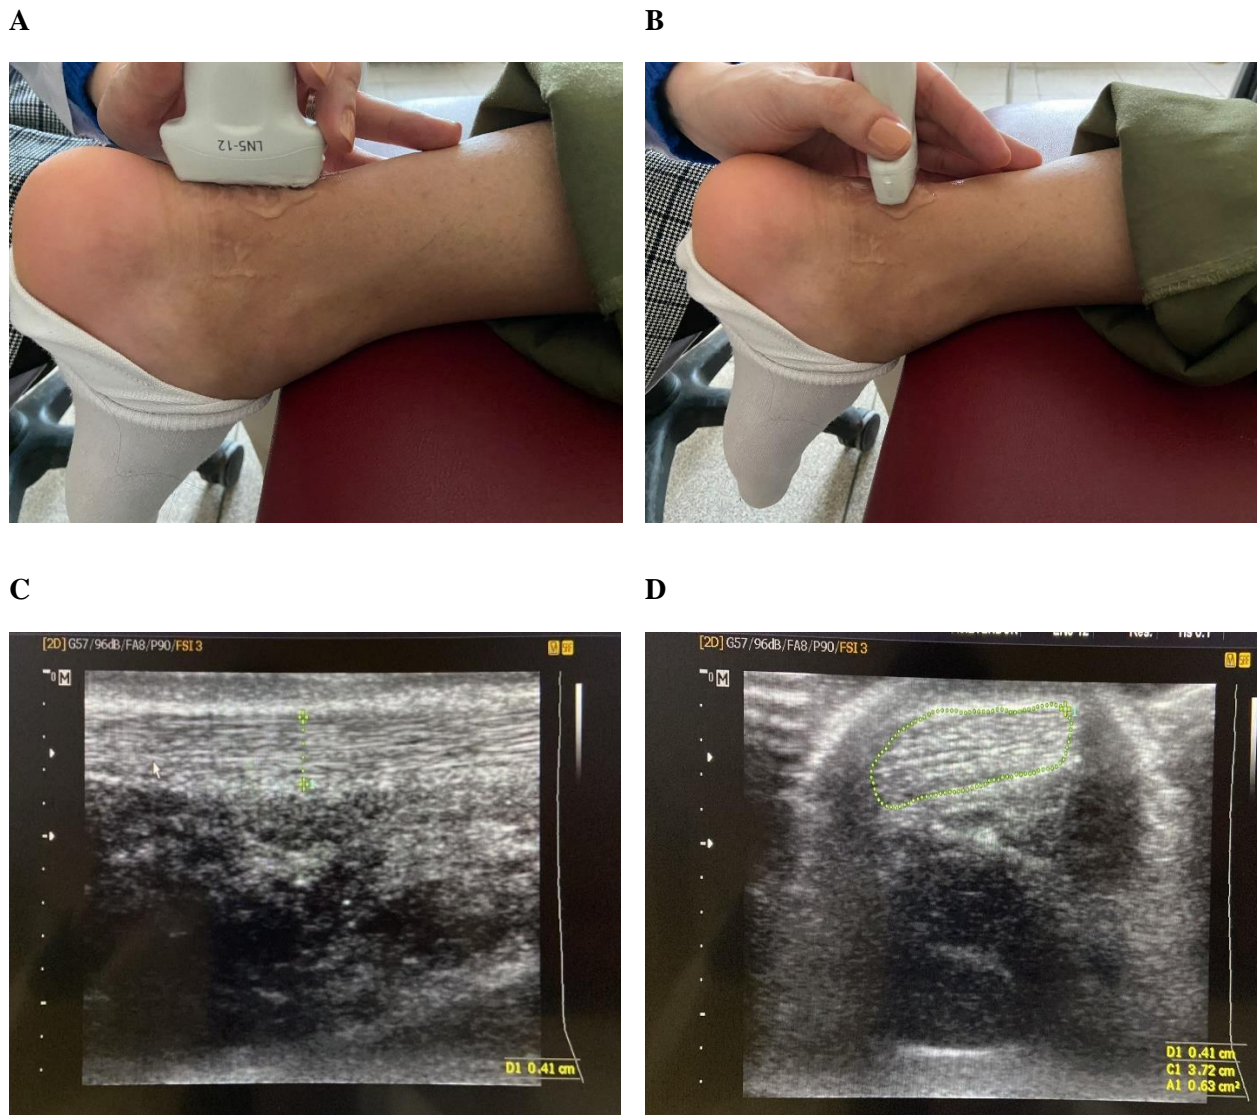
Ultrasound imaging of the Achilles tendon. (A) The transducer is positioned parallel to the tendon to allow measurement of the tendon thickness in the sagittal plane. (B) The transducer is positioned transverse to the tendon at the medial malleolus level to allow measurement of the tendon cross-sectional area. (C) Achilles tendon thickness in the long axis. (D) Achilles tendon cross-sectional area in the transverse axis.
